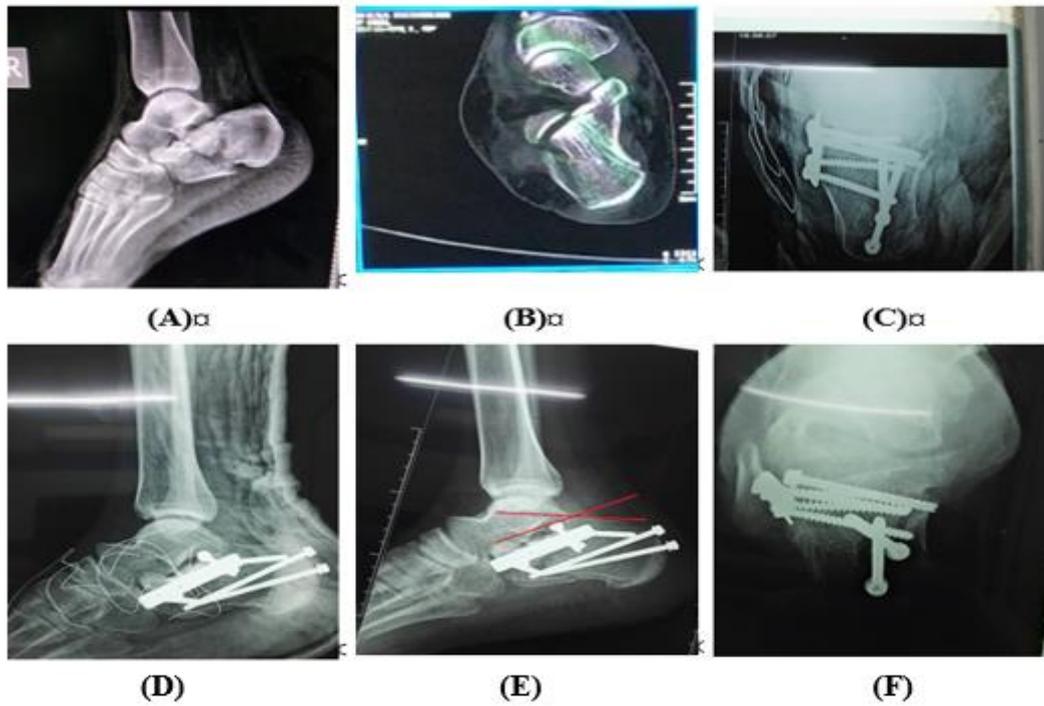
Case I: (A) pre-operative X-ray, (B) pre-operative CT (C, D) immediate post-operative X-ray, (E, F) follow up X-ray after six months, (Sinus tarsi approach have been used).
